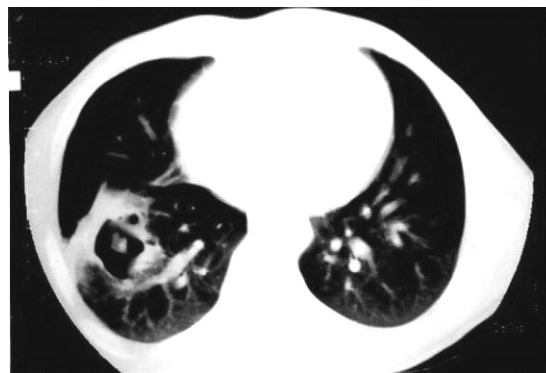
Chest CT scan of patient.
